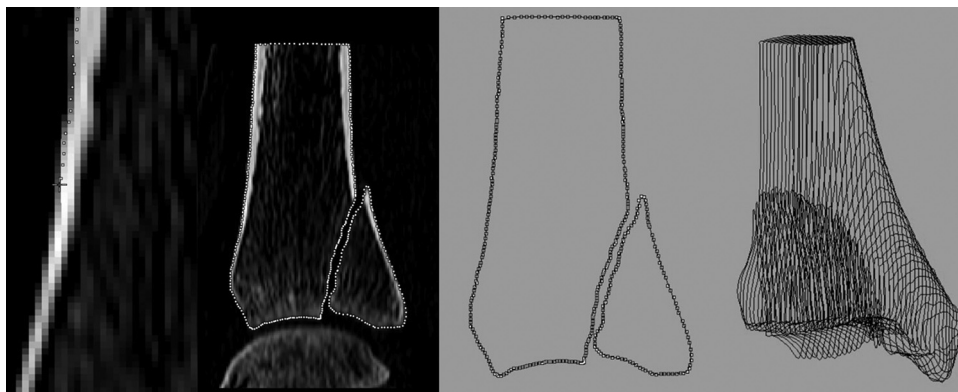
On the left the cortex of the bone is marked on sagittal CT slices. On the right the wire model is seen after combining multiple slices.
